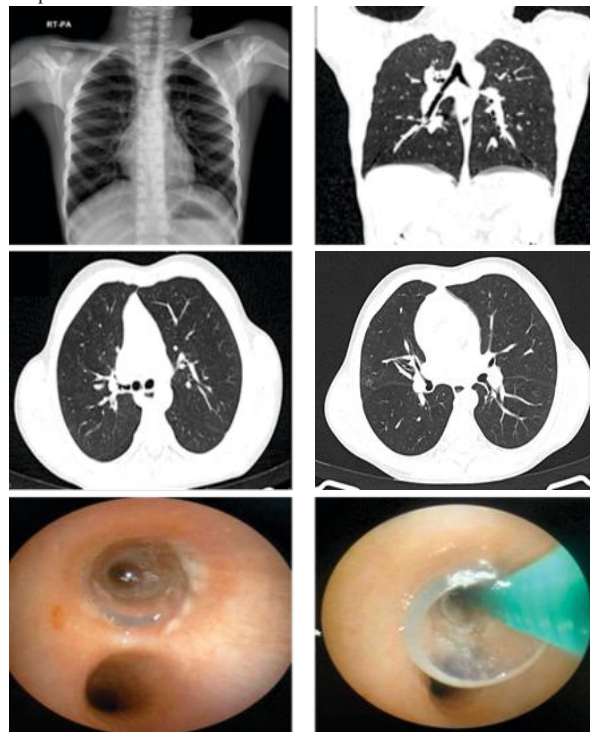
A) Chest radiograph is unremarkable. B and C) Coronal and axial plain CT thorax (lung window) views show significant luminal narrowing of right upper lobar bronchus with wall thickening and irregularity. Faint curvilinear intraluminal structure seen within the right main bronchus D) Subtle centrilobular and subpleural ground glass nodular opacities seen in right upper and middle lobes. E and F) Flexible bronchoscopy images showing plastic pen cap retrieved from the right main bronchus.
